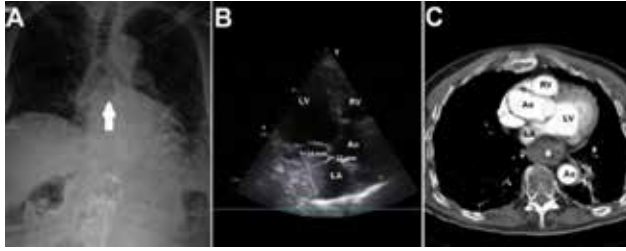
(A) Chest X-ray shows normal mediastinal and cardiothoracic ratios with the suspicious view of air space under tracheal bifurcation (white arrow indicates the air space). (B) Transthoracic echocardiogram in modified 4 chamber view shows left atrial mass in dimensions of 33x34 mm adjacent to lateral atrial wall. (C) Cardiac computed tomographic scan shows that left atrium was compressed by the paraesophageal sliding hernia (white asterisk shows the hernia).
